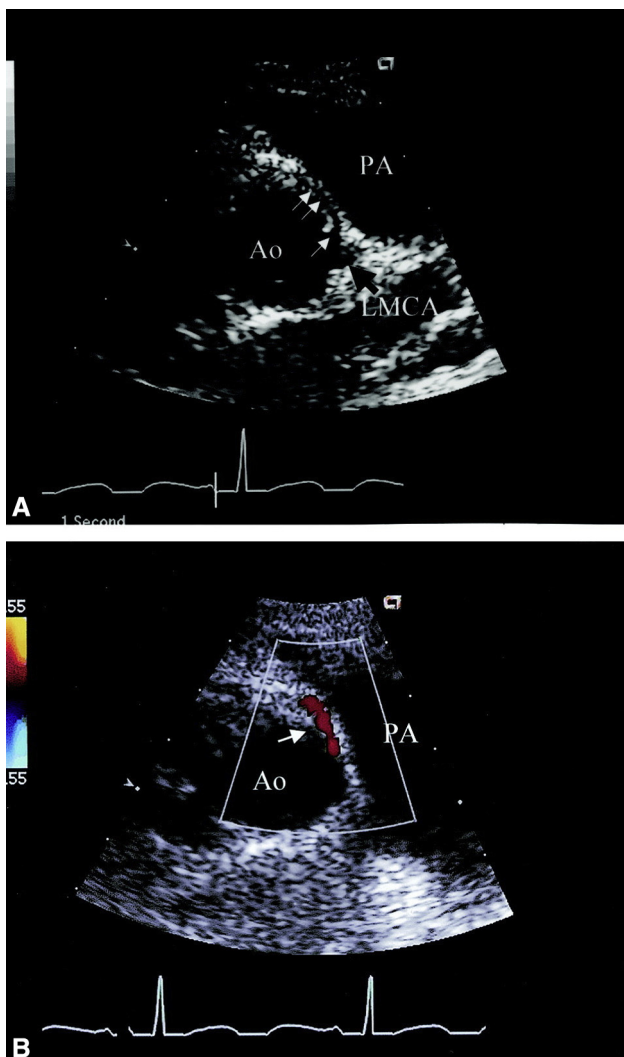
Transthoracic echocardiography from a short-axis plane in a patient with anomalous origin of the right coronary artery from the left sinus of Valsalva and an intramural course of the anomalous coronary. A, The anomalous right coronary artery can be seen arising from the left sinus of Valsalva near the origin of the left main coronary artery (LMCA) and coursing intramurally within the anterior aortic wall (arrowheads) between the aorta (Ao) and the pulmonary artery (PA) toward the right sinus of Valsalva. B, Color Doppler imaging shows the linear diastolic flow of the anomalous coronary within the anterior aortic wall (arrow); the red color signal confirms anomalous coronary flow towards the transducer anteriorly, consistent with the coronary originating from the left sinus and coursing toward the more anteriorly positioned right sinus. Reprinted with permission.⁵³
